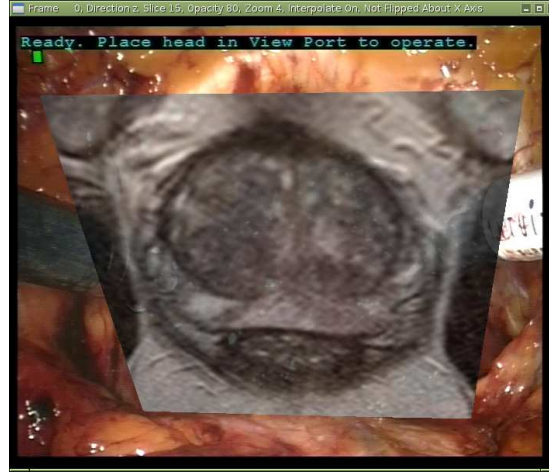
An example of a transverse slice of MRI overlaid on a typical endoscopic scene. The overlay software projects the MRI using a model of the endoscope so that the MRI appears to be coincident with the visible anatomy. The projection software allows the surgeon to change the opacity of the projection or move through the MRI data in the transverse, sagittal, or coronal planes.
